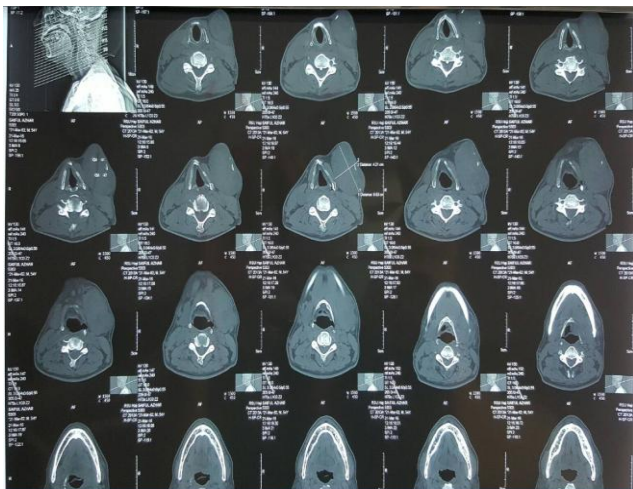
Neck CT Scan (soft tissue tumour size 6.63 x 4.21 cm in the left submandibular)
